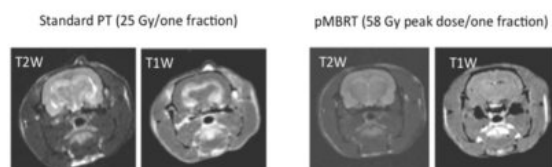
Comparison of  $T2_w$  and  $T1_w$  after Gd injection MRI sequences in the case of standard PT (left) and in pMBRT (right). The images were acquired 7 months after irradiation. Important lesions (hematomas, edemas) are observed in the  $T2_w$  images, as well as an extensive BBB breakdown in the standard PT case. The images corresponding to the pMBRT irradiation showed no significant damage.
